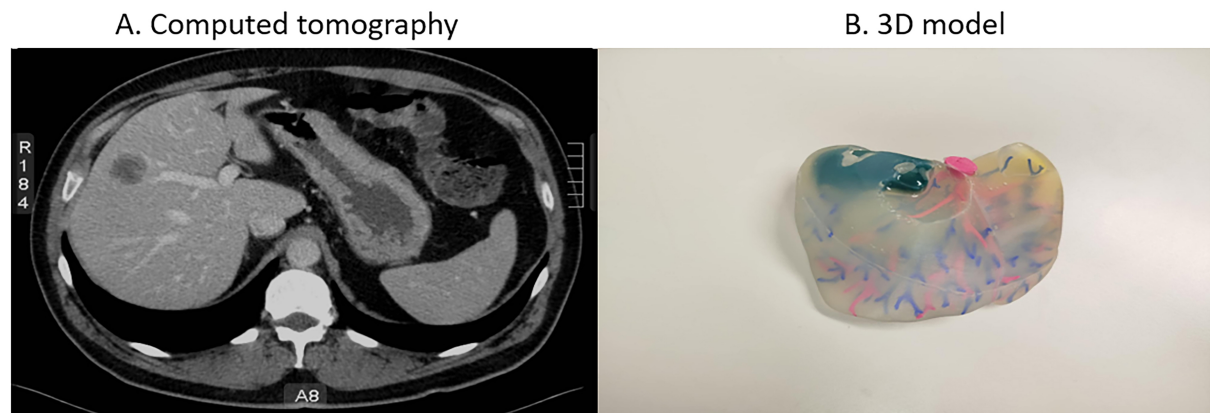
(A) Computed tomography scan of a patient with right liver lobe hepatocellular carcinoma; (B) The 3D-printed liver model of the same patient. The right liver lobe carcinoma is marked with blue ink.
